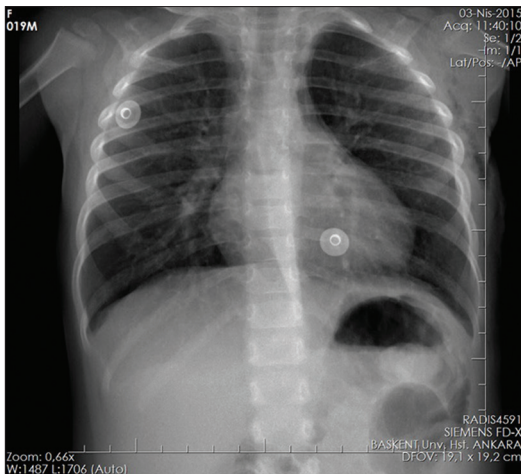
The control chest radiograph that was taken before discharge was normal
